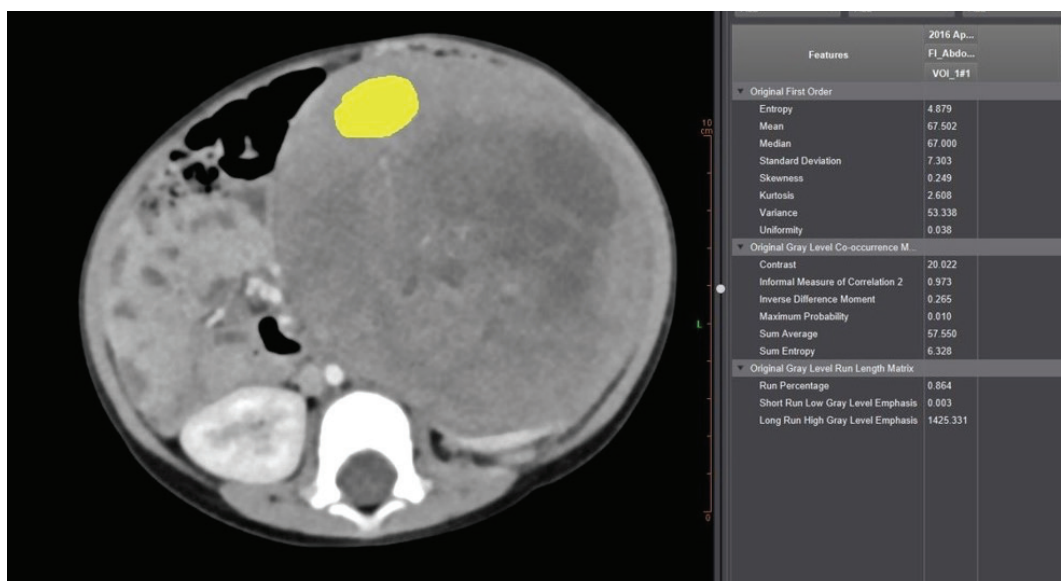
Axial contrast-enhanced CT images: the tissue analysis program monitors the ROI area (yellow area) drawn on the solid mass originating from the left kidney, along with the tissue analysis results of the statistical parameters in the case with WT
